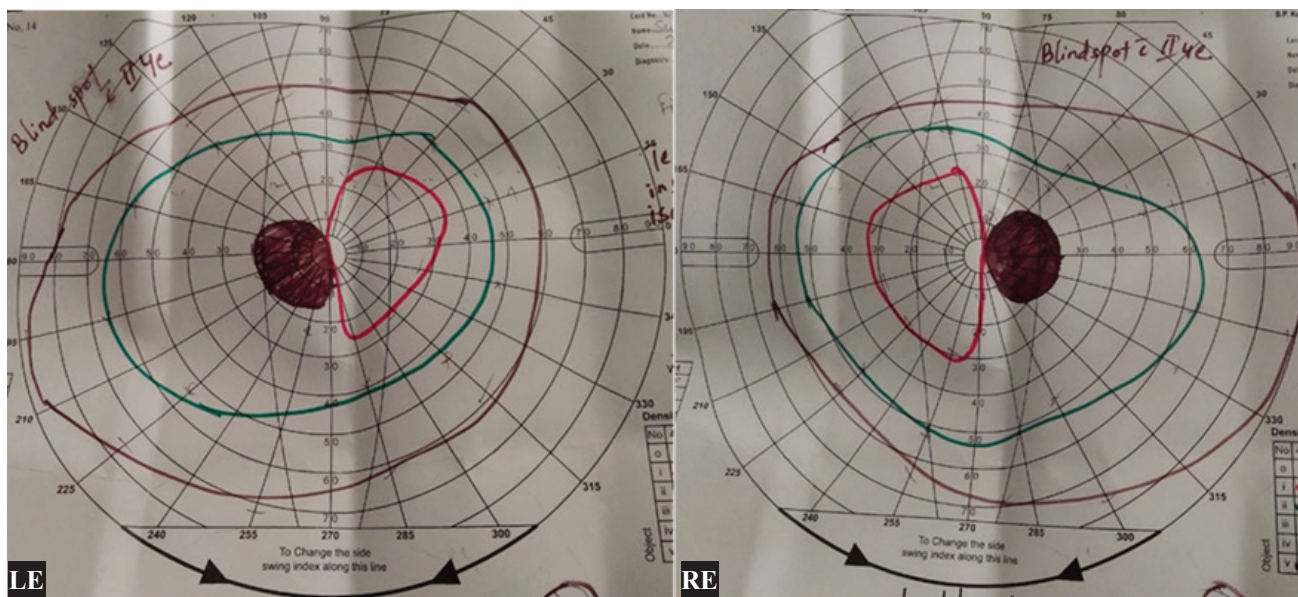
Goldman visual field of a 43 year old female of both eyes showing reduction of central sensitivity in both eyes in the temporal side hinting bitemporal hemianopic scotoma. MRI of the brain showed pituitary macroadenoma.
